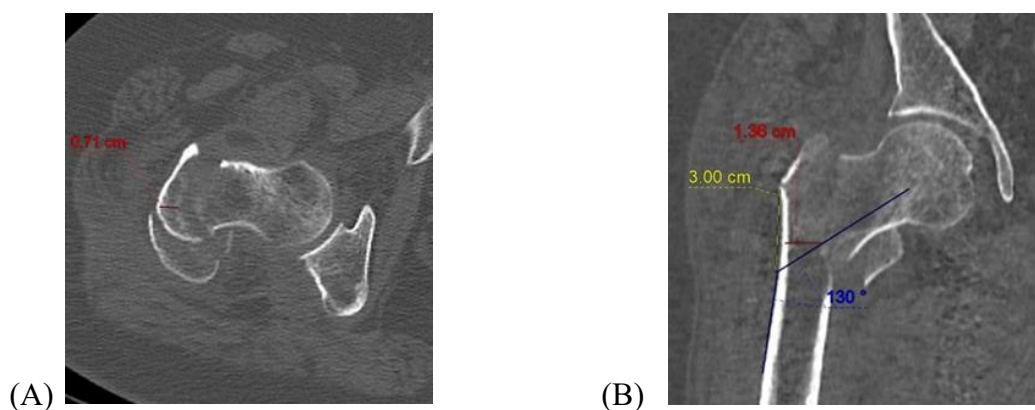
(A) Axial - CT Scan image measuring the lateral wall thickness at the central quadrant as 0.71cm. (B) Coronal - CT Scan image measuring lateral wall thickness, 3cm below lateral ridge along 130-degree neck shaft angle as 1.36cm
